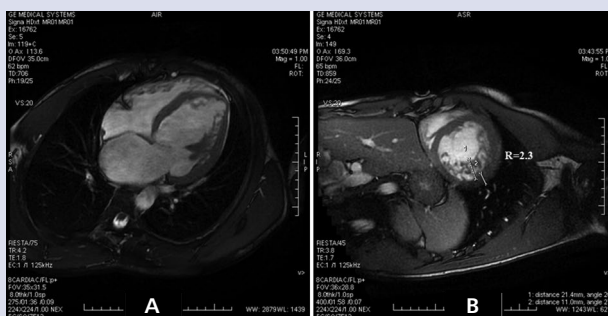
Cardiac magnetic resonance imaging revealing a bilayered aspect of the lateral wall (A), with diastolic ratio of non-compacted-to-compacted myocardial wall of 2.3 (B)
